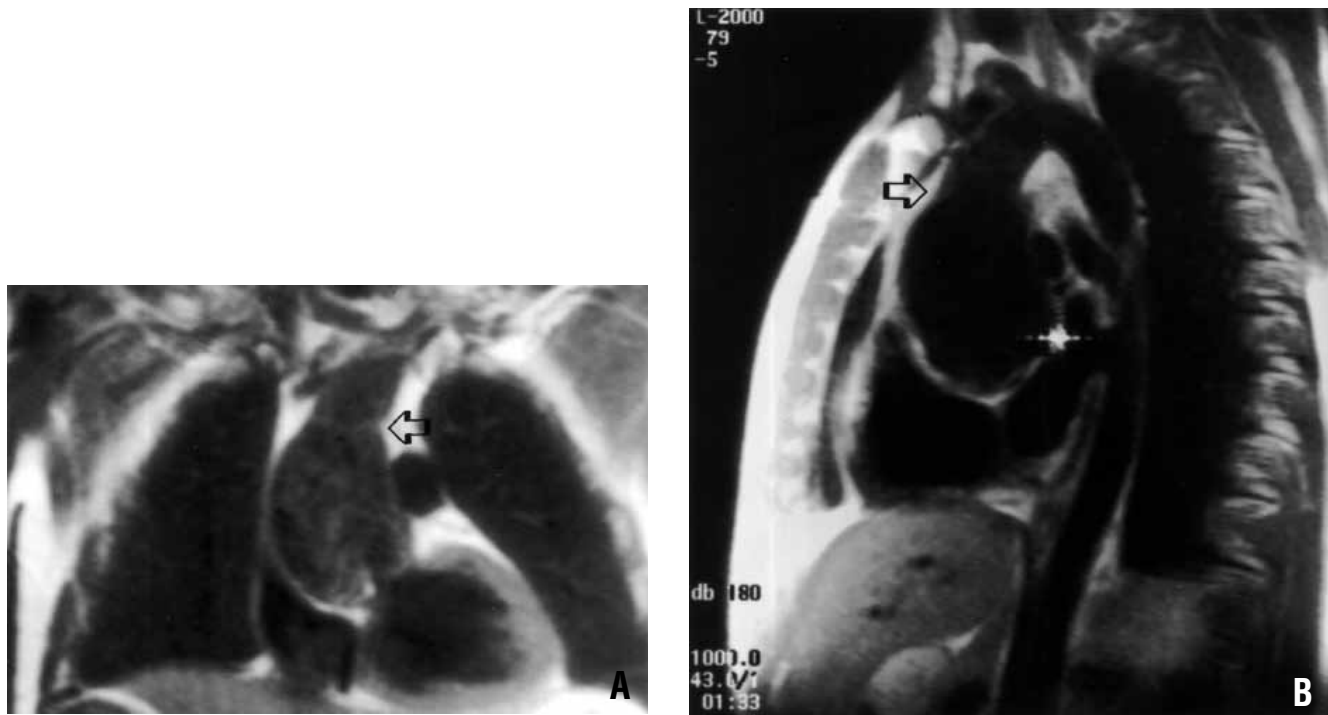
Magnetic resonance images of the neo-aortic root demonstrating dilatation of the pulmonary autograft and an abrupt transition to normal aortic diameter at the distal suture line (*arrow*) in the coronal section (A) and sagittal section (B).
